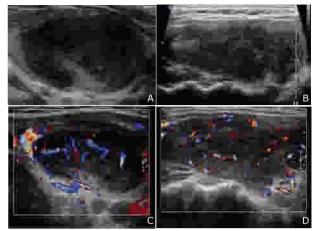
Conventional ultrasonography shows heterogeneous hypoechoic nodule in the left lobe (A) and hypoechoic area in the right lobe with interspersed linear echogenic strands (B). Color Doppler shows abundance of blood flow in the hypoechoic nodule in the left lobe (C) and abundance of blood flow in the hypoechoic area in the right lobe (D).
